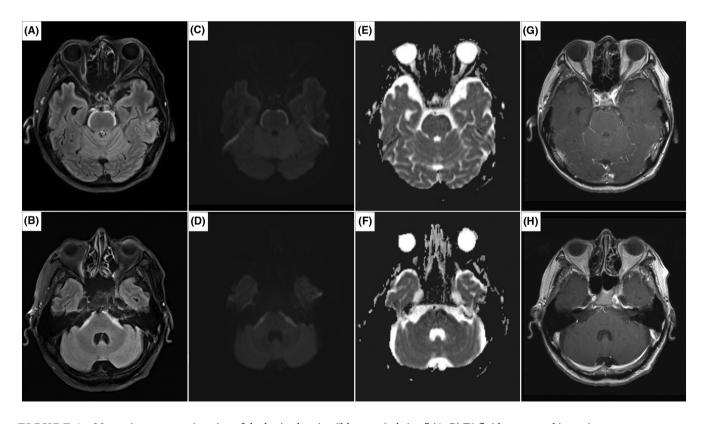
Magnetic resonance imaging of the brain showing "bloomy rind sign." (A, B) T2 fluid-attenuated inversion recovery sequences, showing linear hyperintensities outlining the anterior aspects of the pons and middle cerebellar peduncle, respectively. (C, D) Diffusion weighted sequences, showing restricted diffusion over the same areas. (E, F) Apparent diffusion coefficient sequences, showing hypointensity over the same areas. (G, H) Gadolinium-enhanced T1 sequences, showing lack of abnormal enhancement over the same areas.
